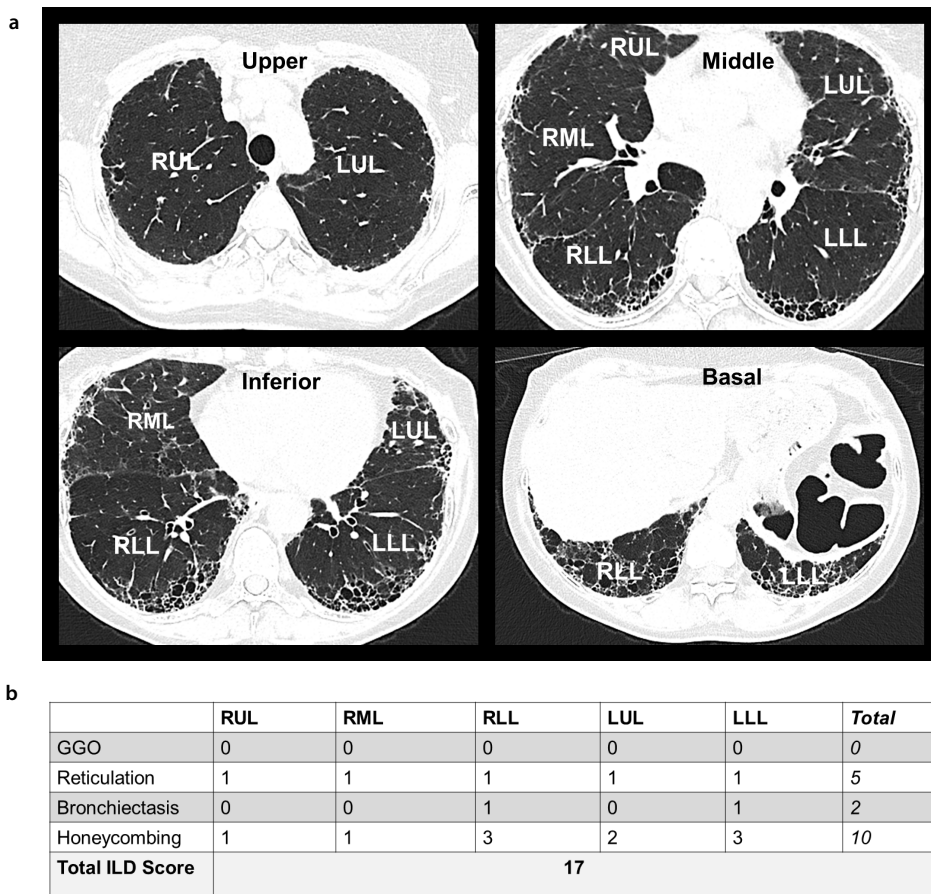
Four UHR CT images of a 68-year-old woman with RA at upper- and mid-level, inferior, and basal costophrenic angles revealed honeycombing, peripheral diffuse reticulation, and traction bronchiectasis with lower-zone dominance consistent with the pattern of definitive usual interstitial pneumonia (a). Lung HR CT score was calculated based on Wangkaew et al.²⁰ (b). RUL, right upper lobe; RML, right middle lobe; RLL, right lower lobe; LUL, left upper lobe; LLL, left lower lobe; RA, rheumatoid arthritis; ILD, interstitial lung disease; UHR, ultra-high-resolution; HR, high-resolution; CT, computed tomography; GGO, ground-glass opacity.
